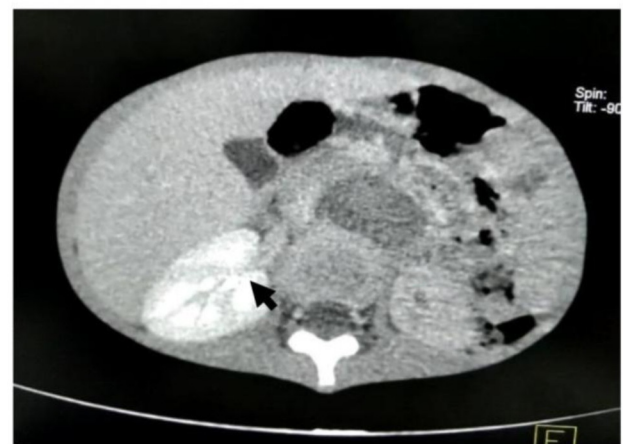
Abdominal CT Scan: oval-shaped mass (black arrow) in the left upper para-aortic region measuring 2.6 x 4.2 x 4.2 cm closely related to the abdominal aorta consistent with a thrombosed abdominal saccular aneurysm probably mycotic seen immediately below the superior mesenteric artery rather than abscess. Hypertrophied right kidney with minimal pelvocaliectasis and a small area of infarct or inflammation. Minimal to moderate hepatomegaly.
